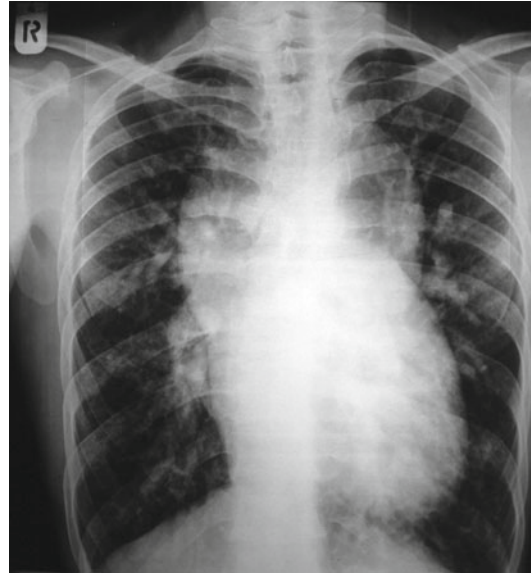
A typical snowman appearance in the chest X-ray. The left-sided dilated vertical vein, the prominent innominate vein on the top, and the right-sided superior vena cava all together give form to a specific image called “snowman sign” or figure of eight
